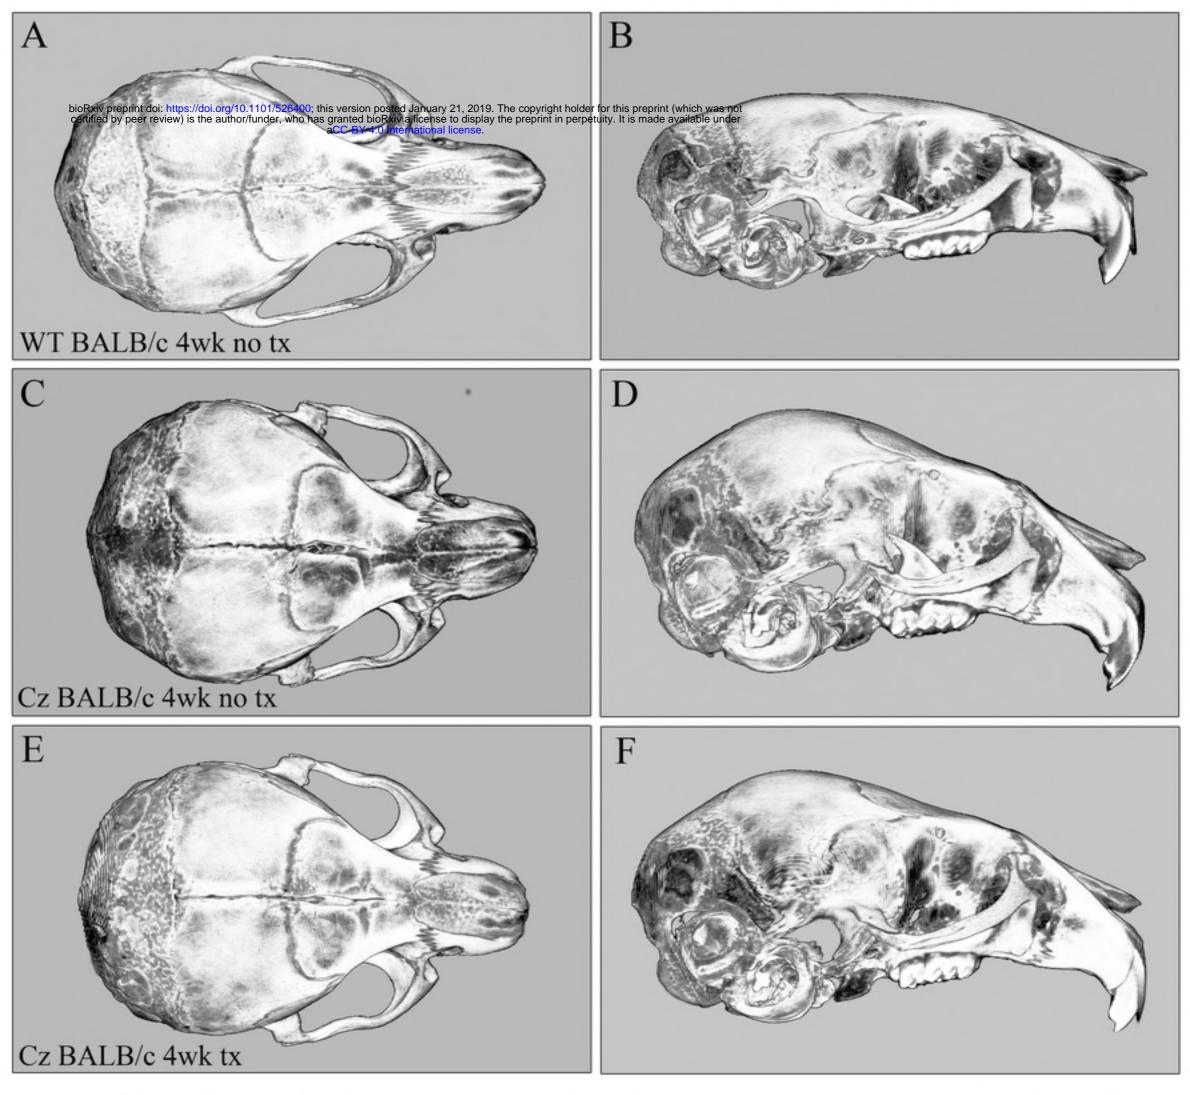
Micro CT images of BALB/c congenic untreated and treated and treated
